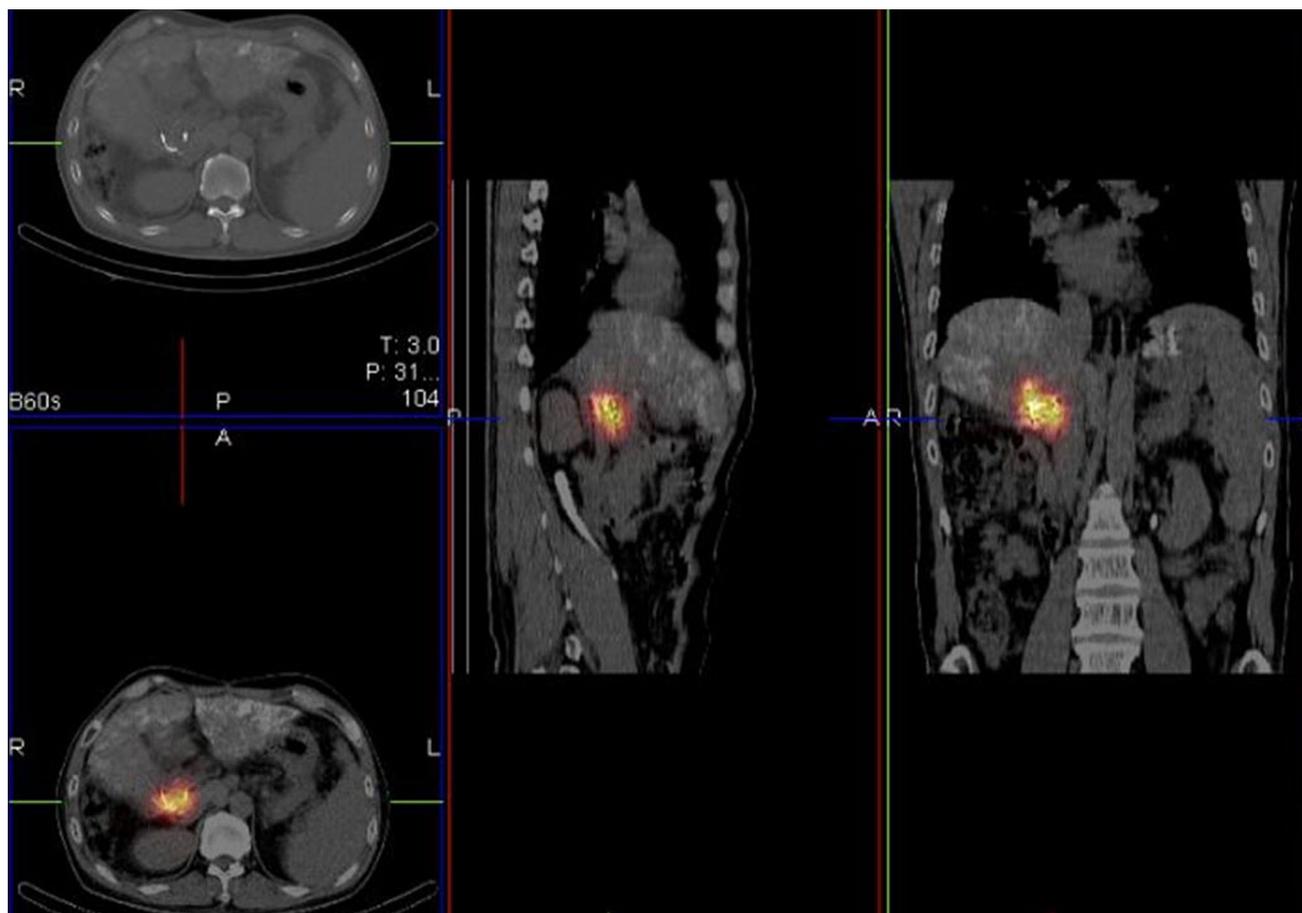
SPECT-CT 2 days after implantation showed the dose distribution covering the tumor thrombosis
